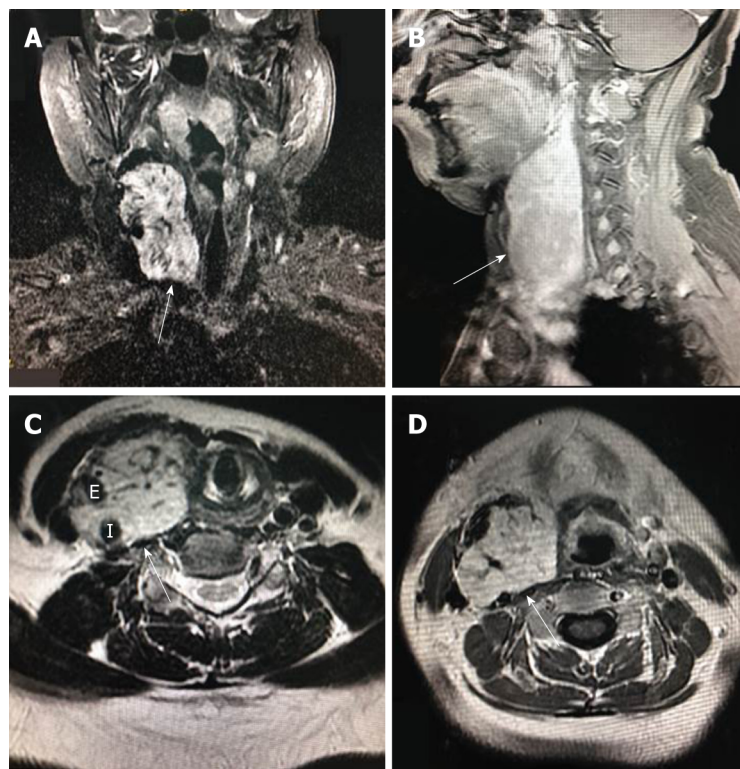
Enhanced magnetic resonance imaging. A: Coronal section (arrow indicates enhancement); B: Sagittal section (arrow); C, D: Axial section showing blood flow in the tumor (arrows). E: External carotid artery; I: Internal carotid artery.
